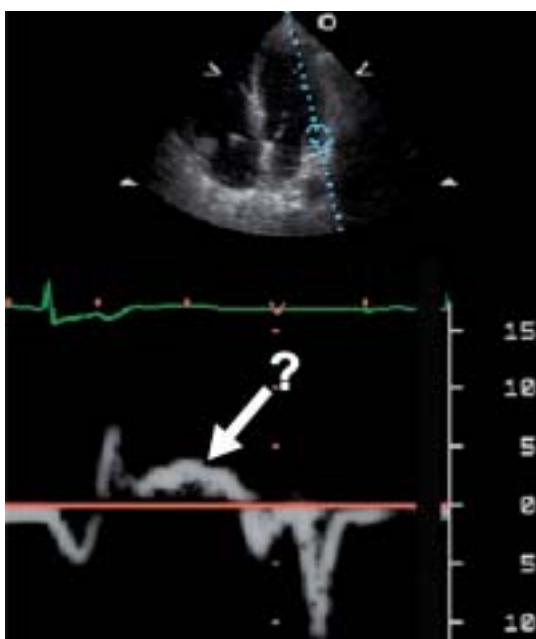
Wall motion velocity spectrum by tissue Doppler imaging. It is difficult to define the end point of peak velocity because of its blunt nature
